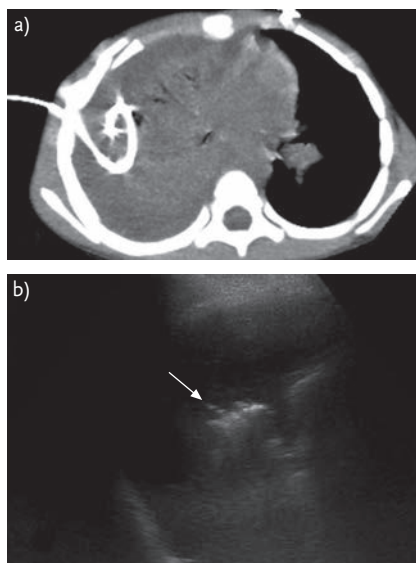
a) A 5-year-old boy with necrotic pneumonia and complicated right pleural effusion. A 10F pigtail catheter was placed under CT guidance for drainage and adjuvant fibrinolytic therapy. A 10-mm multiplanar reconstruction CT image in the axial plane displays the position of the catheter. b) A 10-year-old boy with necrotic pneumonia and right pleural effusion. An 8F pigtail catheter was placed under ultrasound guidance for drainage. The arrow indicates the catheter inside the effusion.
